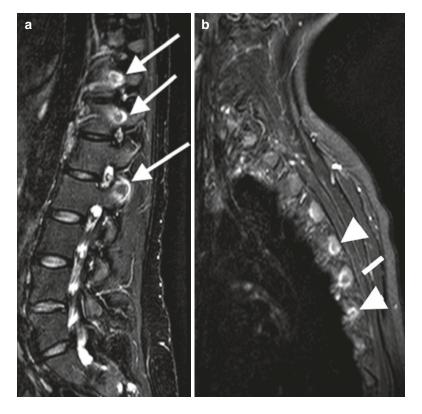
(a) Sag STIR image and MRI image of the lower thoracic spine with costovertebral (*upper 2 arrows*) and costotransverse (*lower arrow*) osteitis and (b) the same patient with the osteitis rib adjacent to the costotransverse joint (*arrowheads*)
